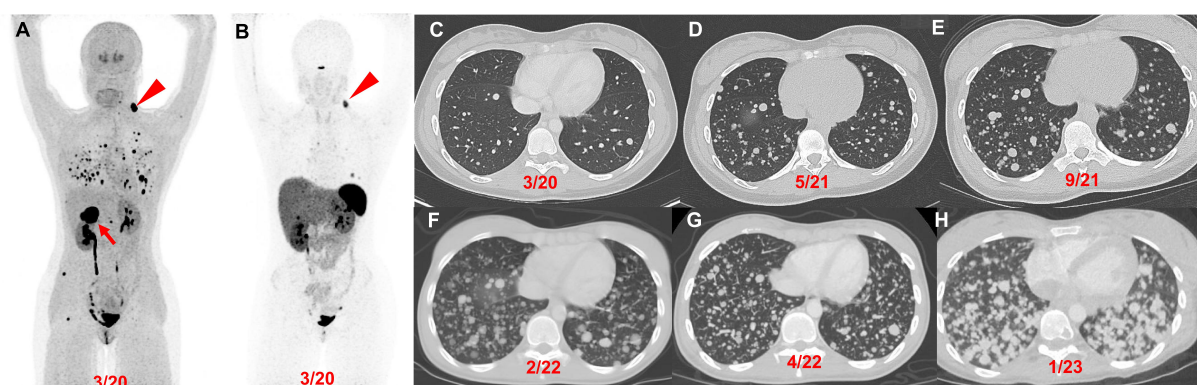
Patient 1 (14-year-old female, *VHL* pathogenic variant), serial images throughout the course of treatment: Anterior maximum intensity projection images of ^{18}F -FDOPA PET/CT (A) and ^{68}Ga -DOTATATE PET/CT (B) demonstrate a 4.4 cm right PCC (red arrow), left parapharyngeal neck mass (red arrowhead), and widespread metastatic lesions in the lungs and bones. Axial contrast CT images (C–H) in the same plane at various time points (03/2020, 05/2021, 09/2021, 02/2022, 04/2022, and 01/2023) show the patient's progression (increase in number of lung lesions and tumor volume) despite therapy (3 cycles of CVD between 12/2021 and 2/2022; 3 cycles of axitinib between 3/2022 and 10/2022; and pembrolizumab and axitinib between 10/2022 and 02/2023). CVD: cyclophosphamide, vincristine, and dacarbazine; PCC: pheochromocytoma
